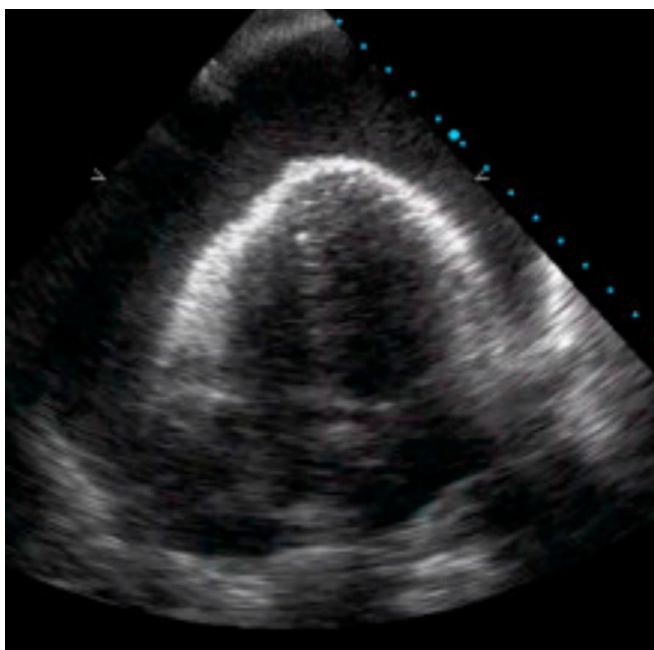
Echocardiographic image showing a significant pericardial effusion
